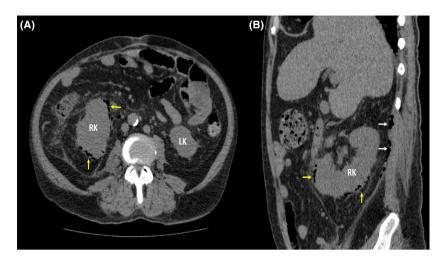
CT scan of the abdomen, transverse (A) and oblique (B) views demonstrating markedly enlarged right kidney with intraparenchymal, perinephric [yellow arrows], and pararenal air [white arrows] consistent with emphysematous pyelonephritis, grade 3B; RK, right kidney; LK, left kidney.
